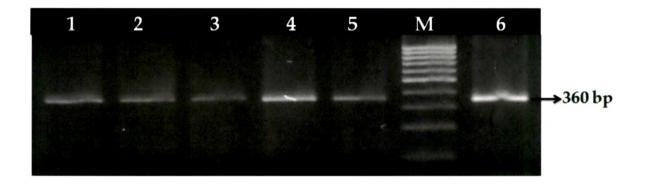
PCR-RFLP analysis of *SOD1* C/T (Ile40Thr) polymorphism on 2.5 % agarose gel electrophoresis: lanes: 1, 2, 3, 4, 5 & 6 show individuals with homozygous CC genotypes; lane M shows 100 bp DNA ladder. No individual with homozygous TT and heterozygous CT was found.
